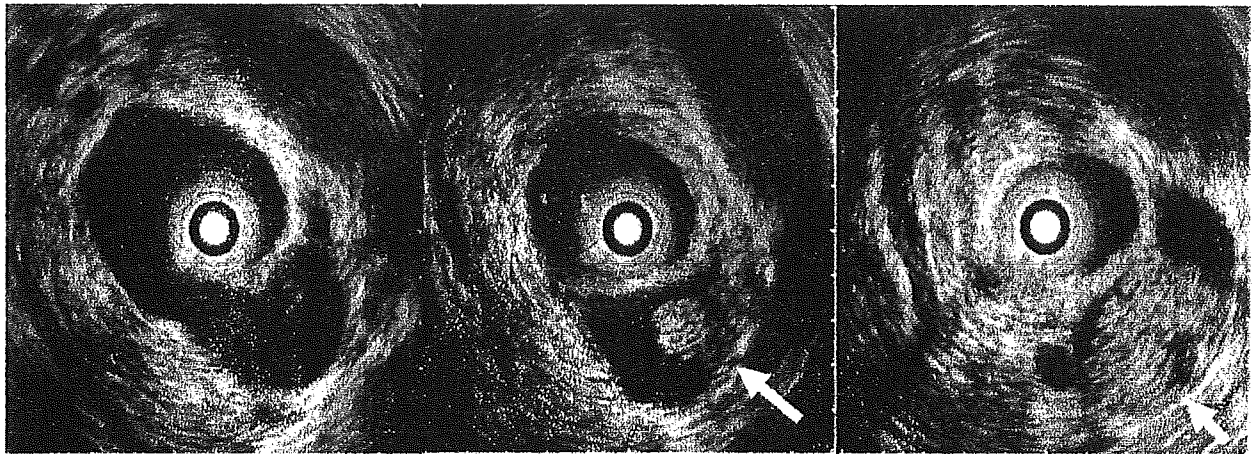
Intraductal ultrasonogram visualizing a mural nodule in a branch duct IPMN in the head of the pancreas (arrows).
